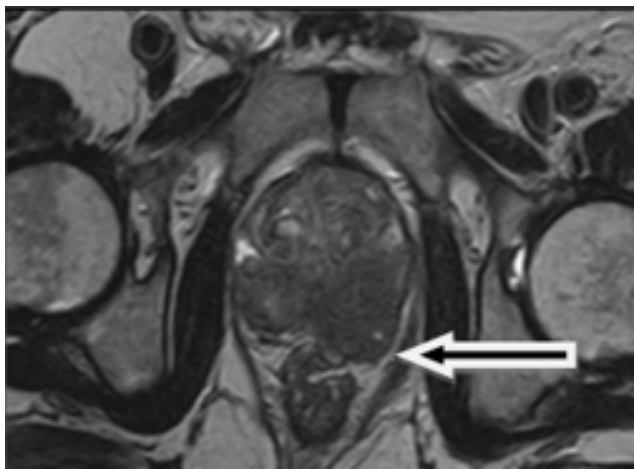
T2 W axial image showing -Appearance of extracapsular extension on MRI
